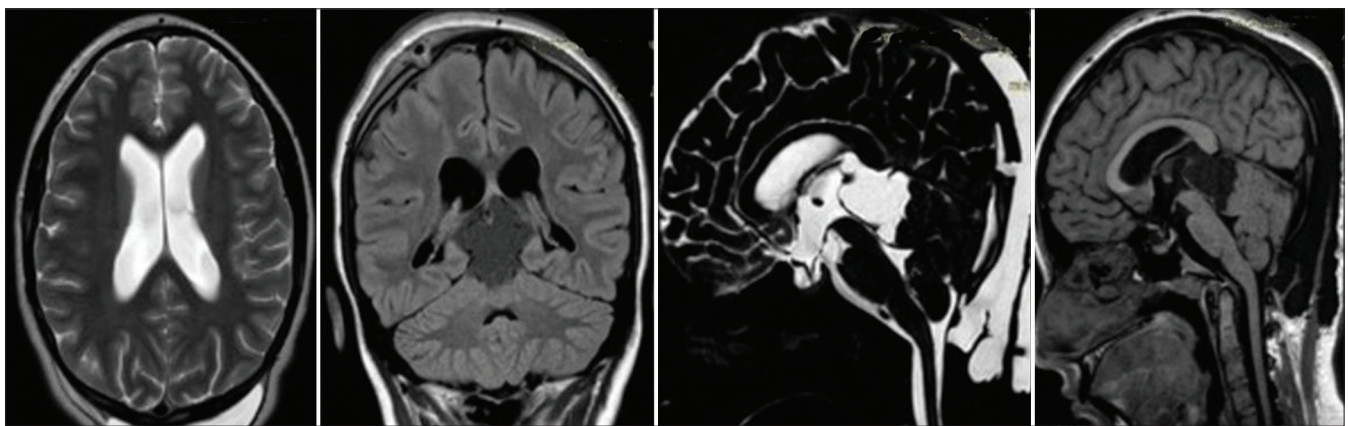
MRI of the brain, 11th day after surgery.
